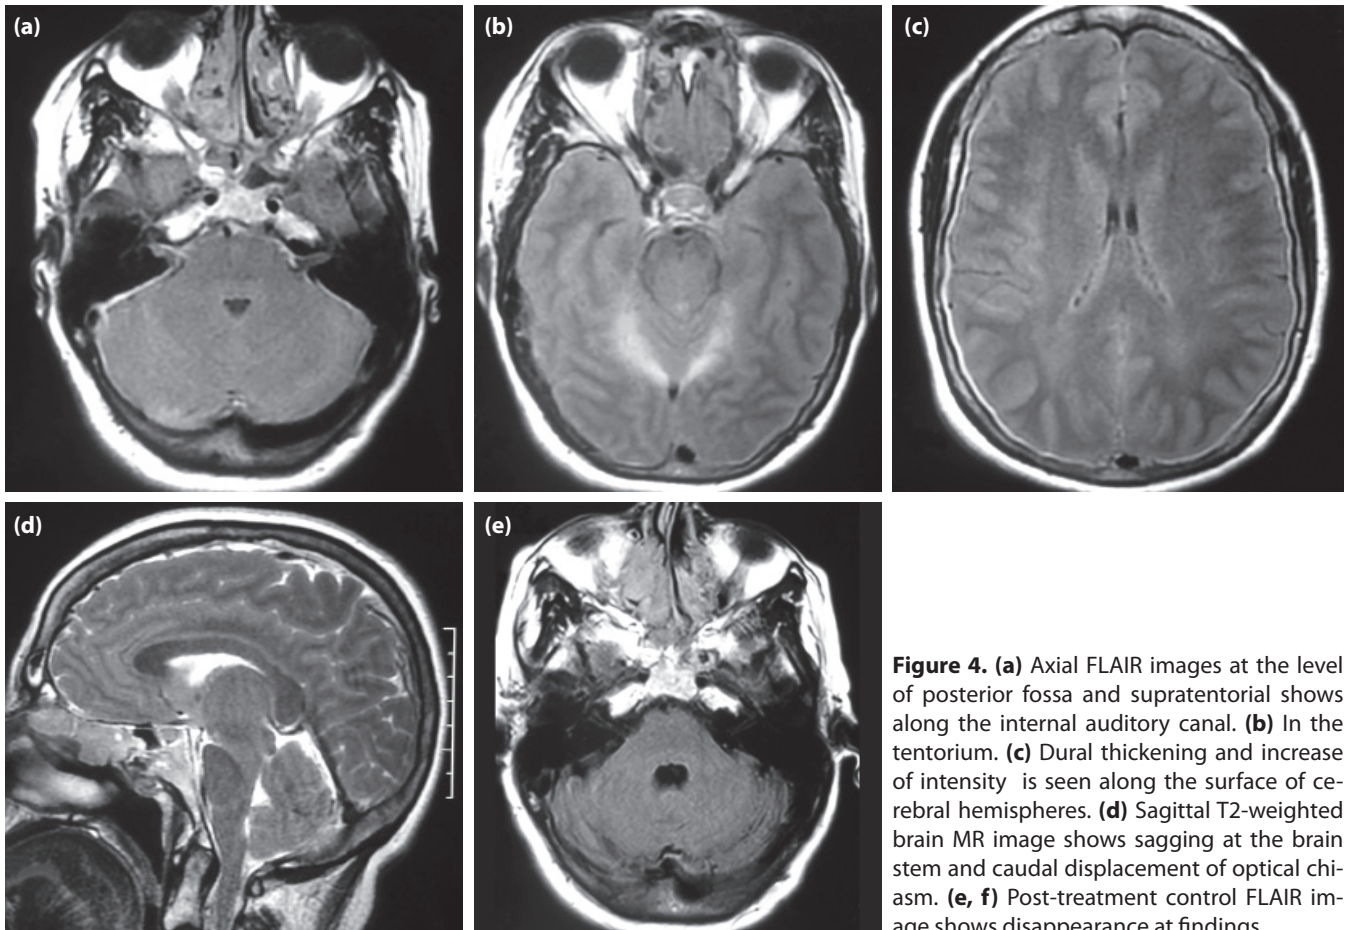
(a) Axial FLAIR images at the level of posterior fossa and supratentorial shows along the internal auditory canal. (b) In the tentorium. (c) Dural thickening and increase of intensity is seen along the surface of cerebral hemispheres. (d) Sagittal T2-weighted brain MR image shows sagging at the brain stem and caudal displacement of optical chiasm. (e, f) Post-treatment control FLAIR image shows disappearance at findings.
